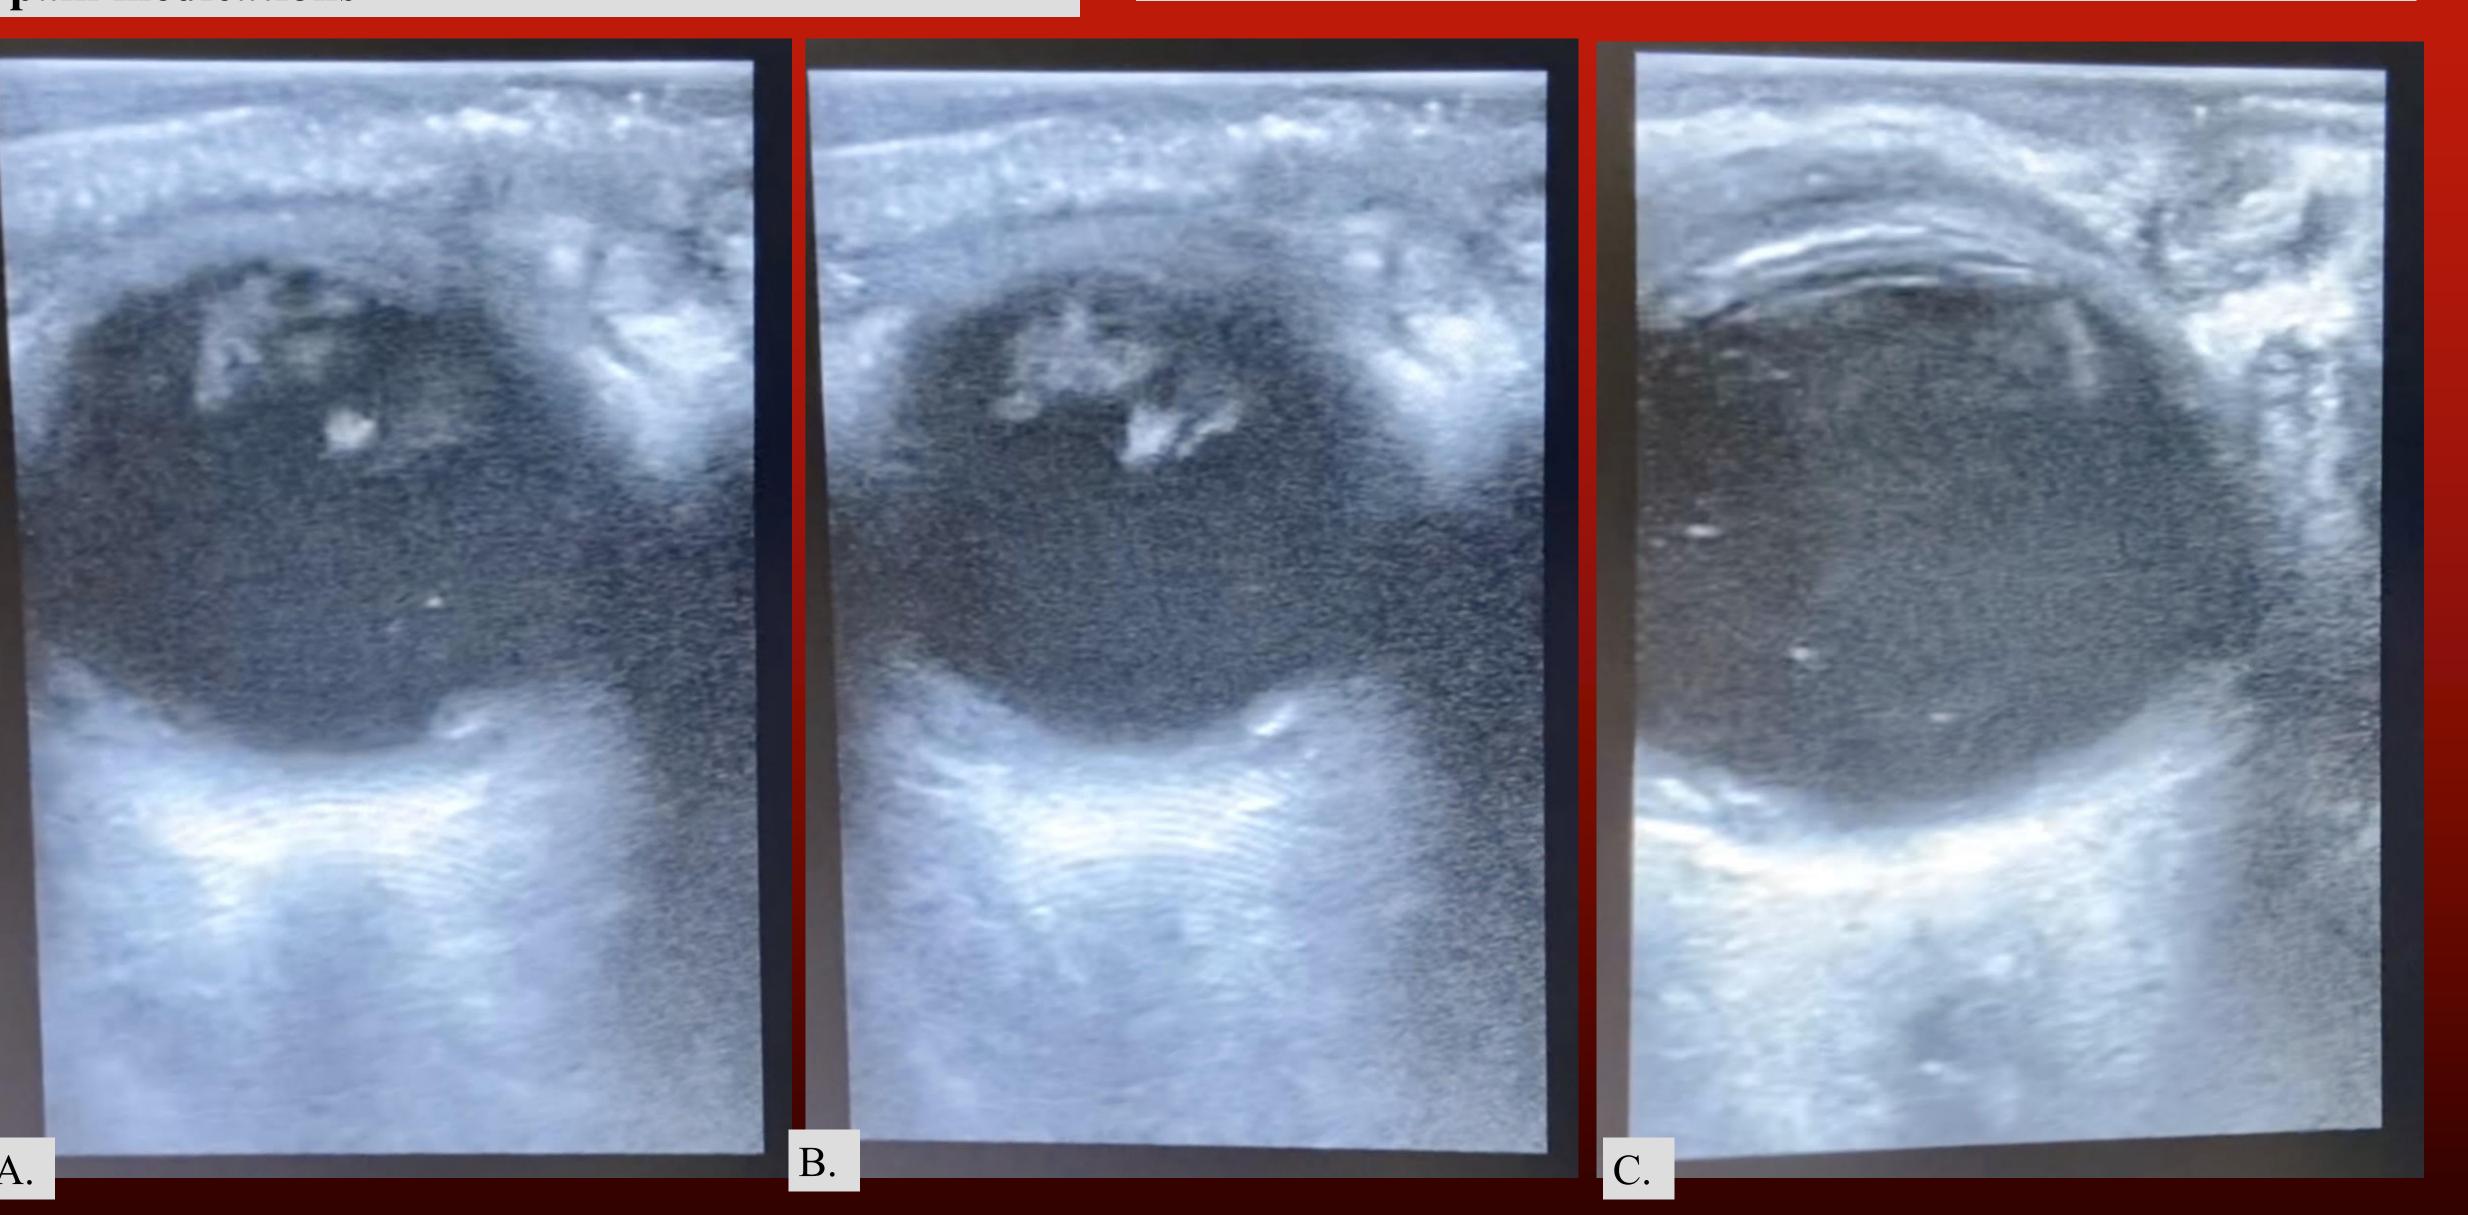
B-Scan Imaging at time of examination [A and B] with signs of vitreitis and presumed endophthalmitis, prior to Vitreous Paracentesis and Intraocular Antibiotics. [C] with continue vitreitis, shadow of steel fiber seen on Ultrasound imaging
